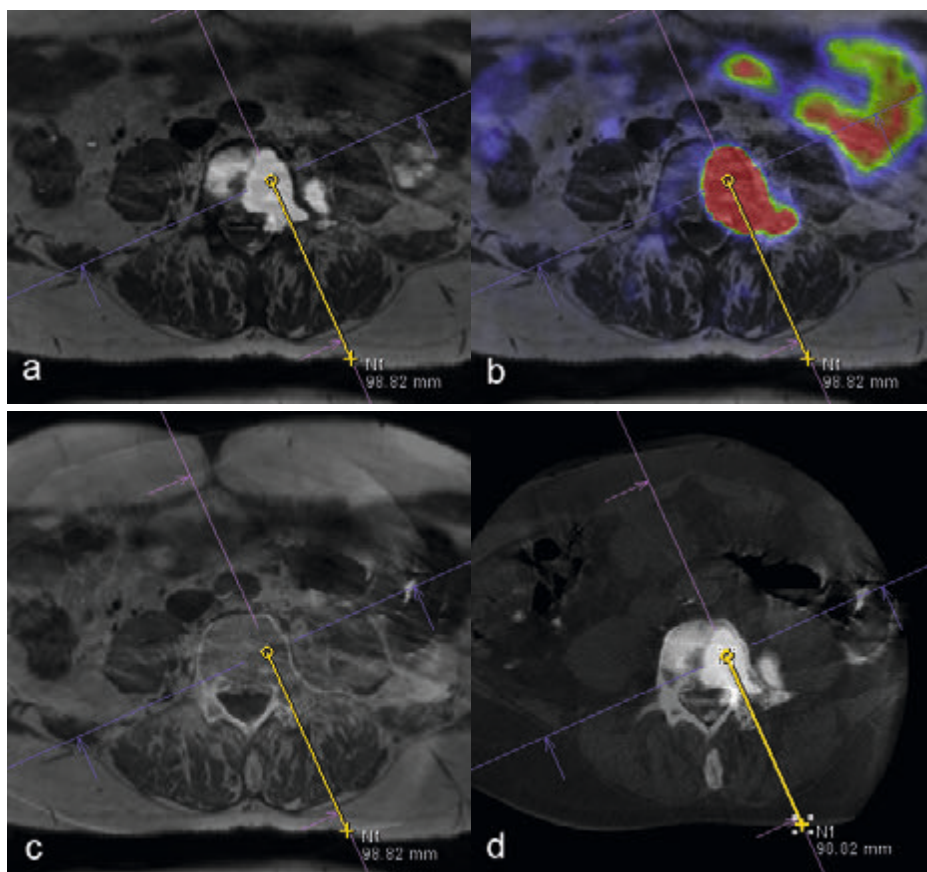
A-D This example shows the target planning of patient 1 on fused datasets. (A) The target was initially planned on a fusion of T1 and b800 images. (B) This target was then verified on a fusion of T1 and ^{68}Ga -PSMA-PET images. (C) The CBCT scan showing the current anatomy was fused with the T1 to optimize the needle path. (D) The CBCT/b800 fusion with needle path was displayed on screens in the room during needle guidance.
